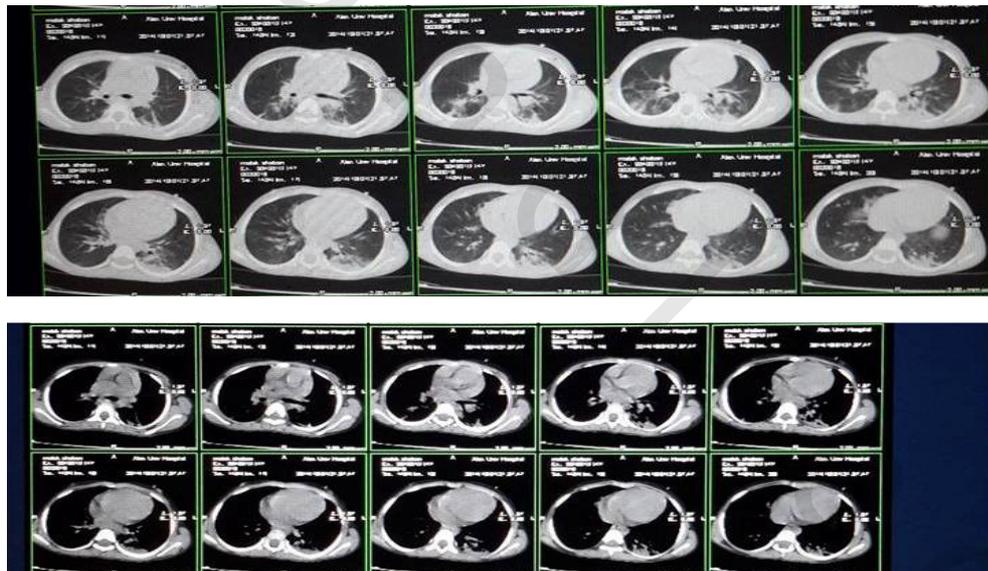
CT chest showing ground-glass opacity, interlobular septal thickening.
